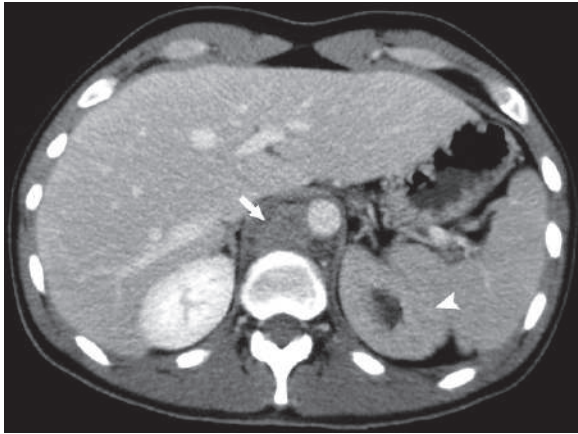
Axial postcontrast CT of a patient with left renal lymphoma shows renal contrast enhancement (*arrowhead*) that is less than the normal right kidney enhancement due to diffuse parenchymal infiltration of the left kidney by lymphoma. Notice the enlarged retroperitoneal paraaortic lymph nodes, which are a good clue for lymphoma (*arrow*)
